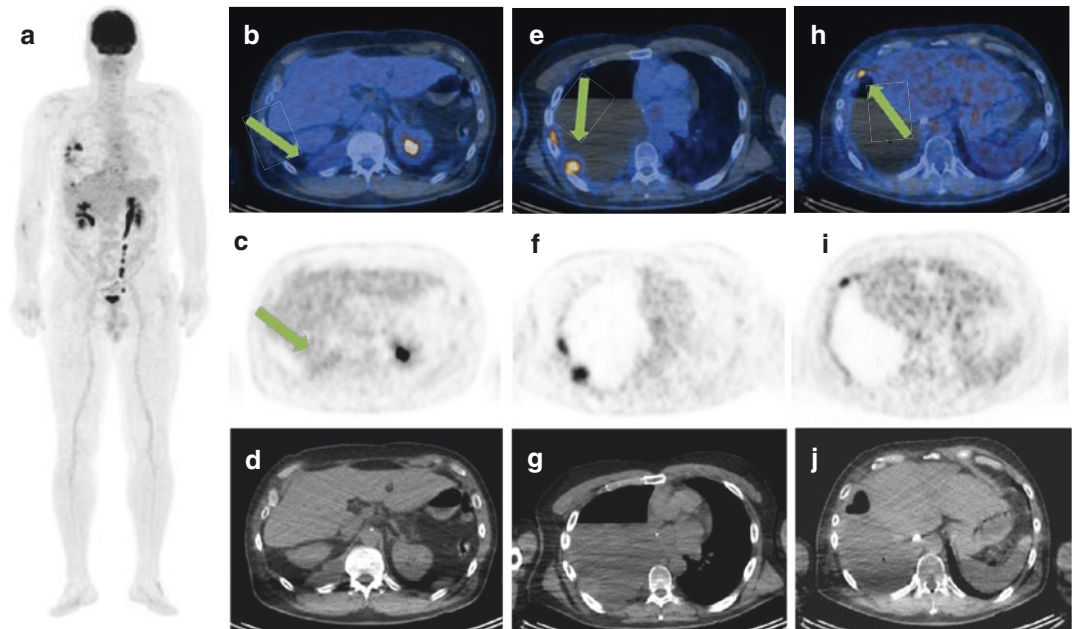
(a) September 2017 FDG PET/CT scan: There are increased tracer uptake within several new hypermetabolic foci in the upper right phrenic region between the right diaphragmatic pillar, the aorta, and the esophagus (SUVmax = 5.3; b–d); presence of two tissue
